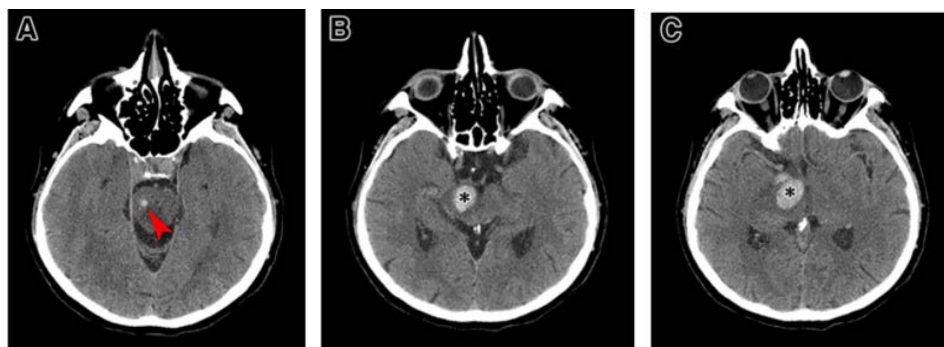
A brain stem hemorrhage in the pons (red arrowhead) (A) and midbrain (asterisk) (B), as an extension of a right thalamic hemorrhage (asterisk) (C) in axial computed tomography scans.
